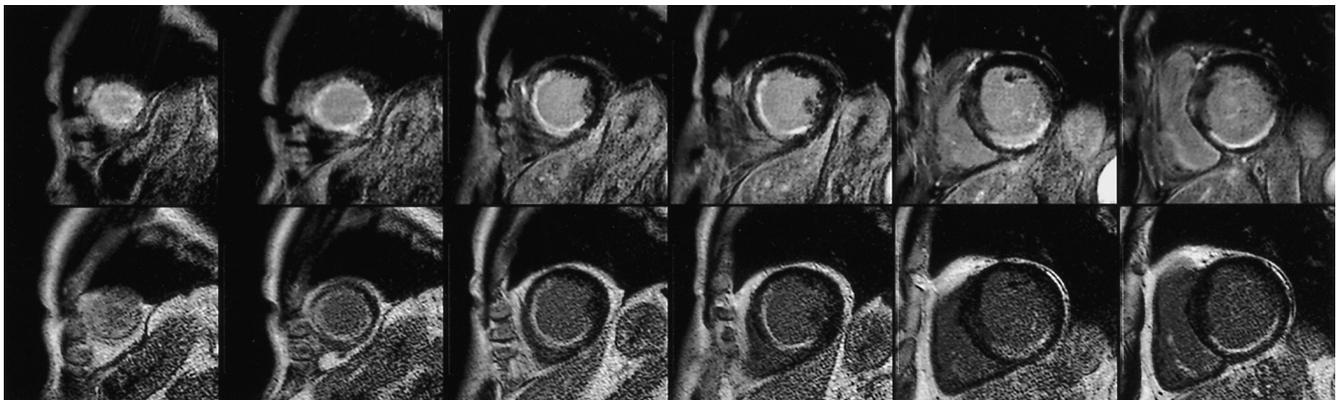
Corresponding short-axis MR images in a 65-year-old male patient.
